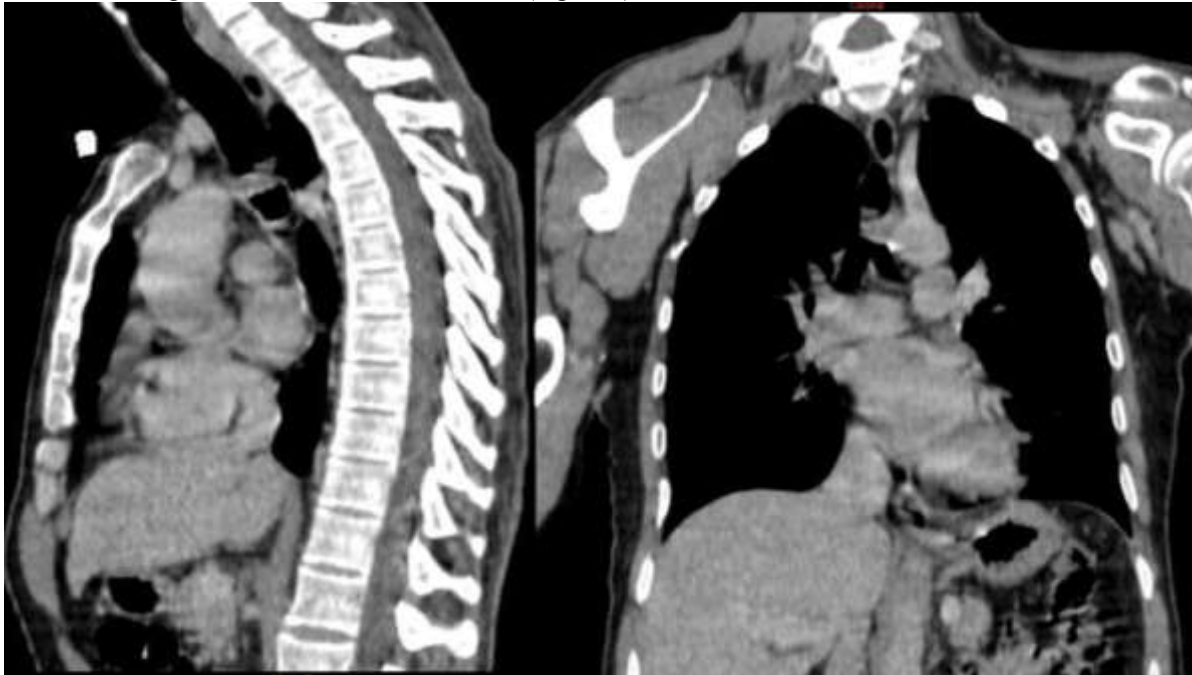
(A, B):- Chest CT in Mediastinal Window: Sagittal and Coronal Sections showing a nearly stenosing intratracheal mass lesion.
